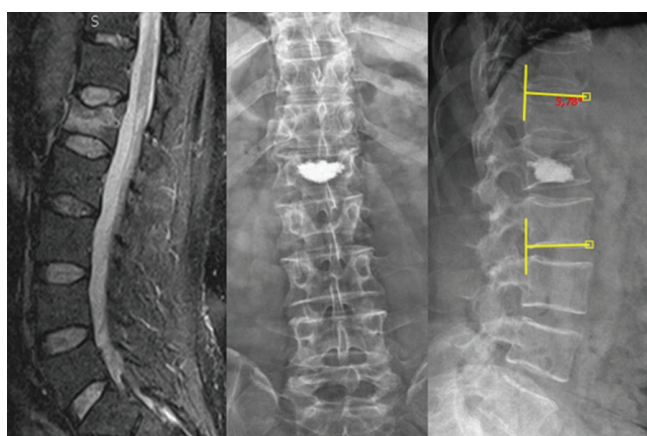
The preoperative MRI (STIR sequence) of the L1 vertebra fracture, postoperative radiographs and the measurement image of the local kyphosis angle
